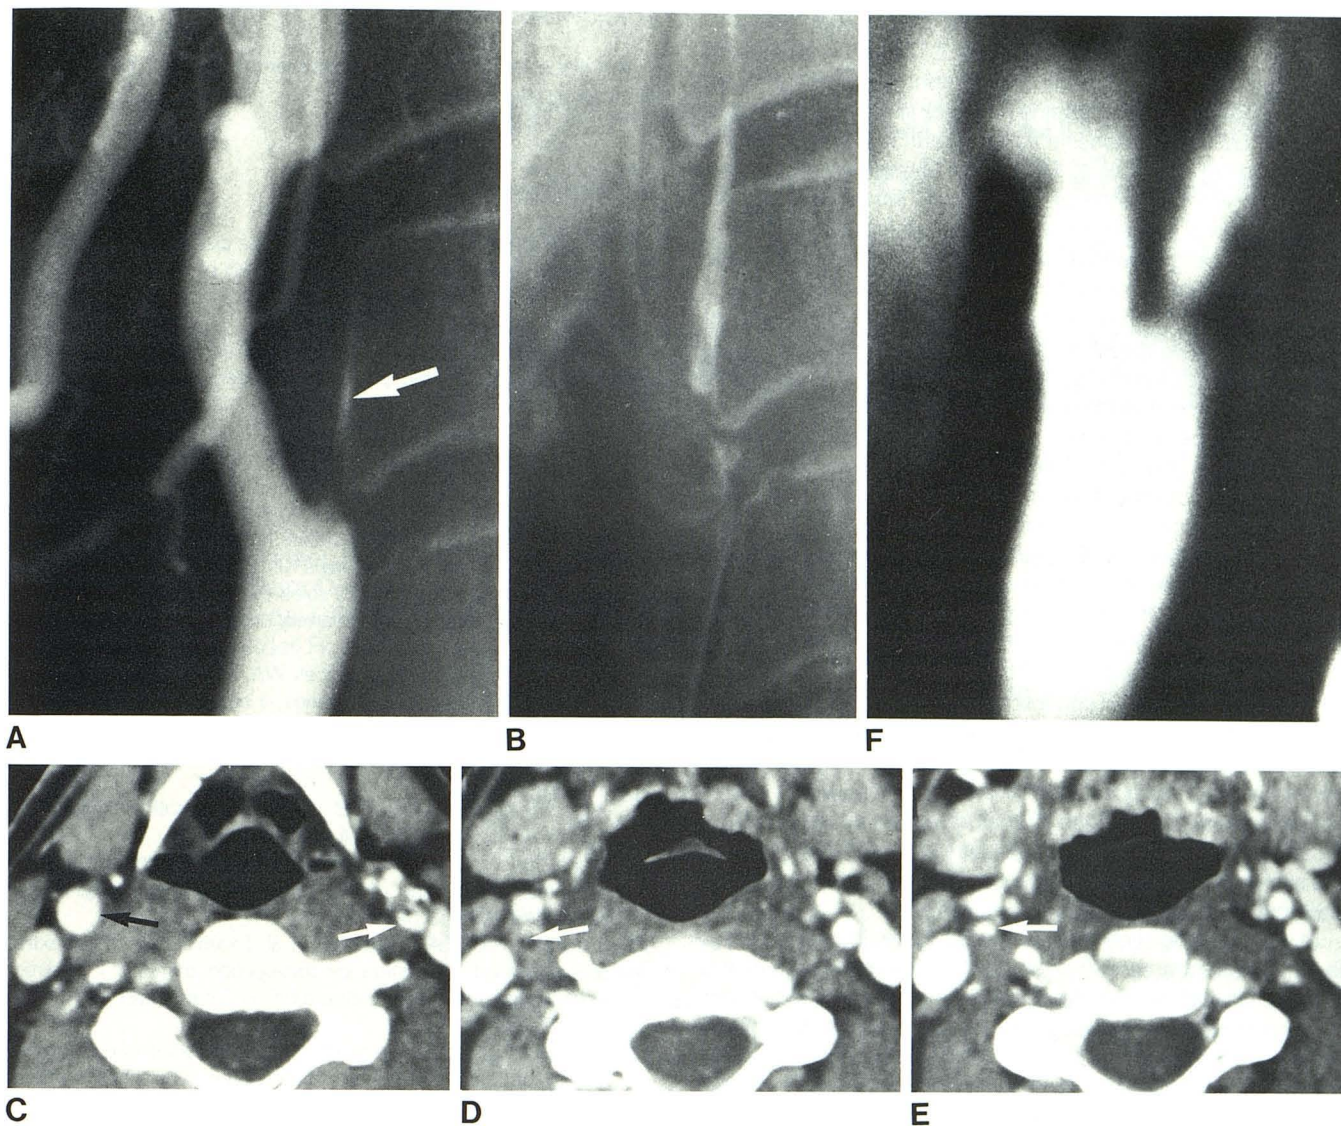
A, Carotid angiogram, arterial phase. Sliver of contrast medium (arrow) in severely stenosed right internal carotid artery. B, Carotid angiogram, venous phase. Very slow passage of contrast medium through internal carotid artery. C, Axial CT scan through neck 3 mm inferior to termination of right common carotid artery. Right common carotid artery is normal (black arrow). Left internal carotid artery is moderately stenosed at its origin (white arrow). D, Axial CT scan through origin of right internal carotid artery. Right internal carotid
